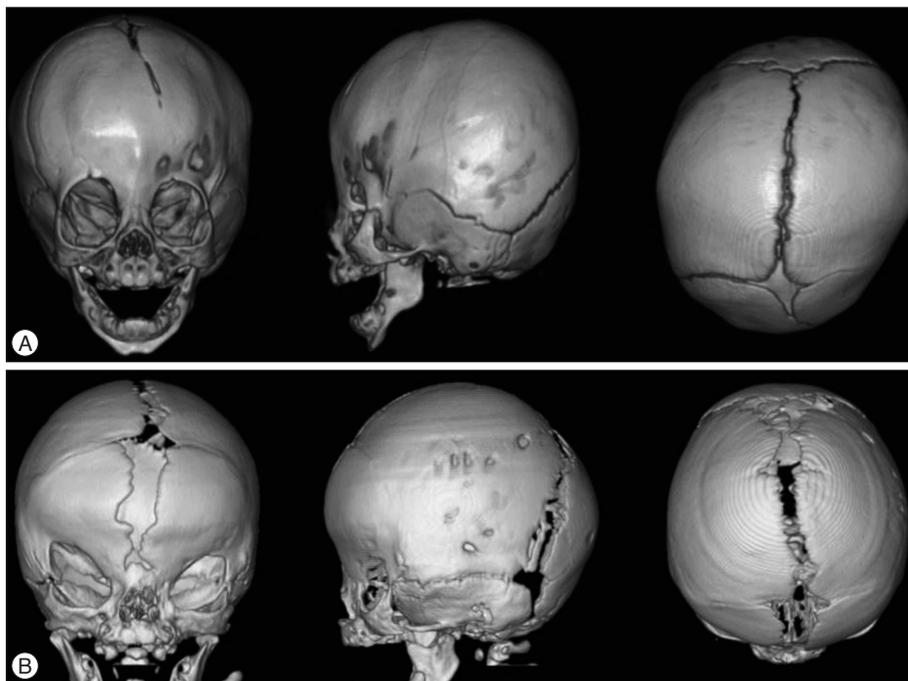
A : Pre-operative 3D CT images show asymmetric skull shape with unilateral (left) coronal synostosis in Saethre-Chotzen syndrome. B : Brachycephaly due to bilateral coronal synostosis, lateral displacement of orbits, and central defects between frontal bones are noted on the 3D CT images in craniofrontonasal syndrome.
